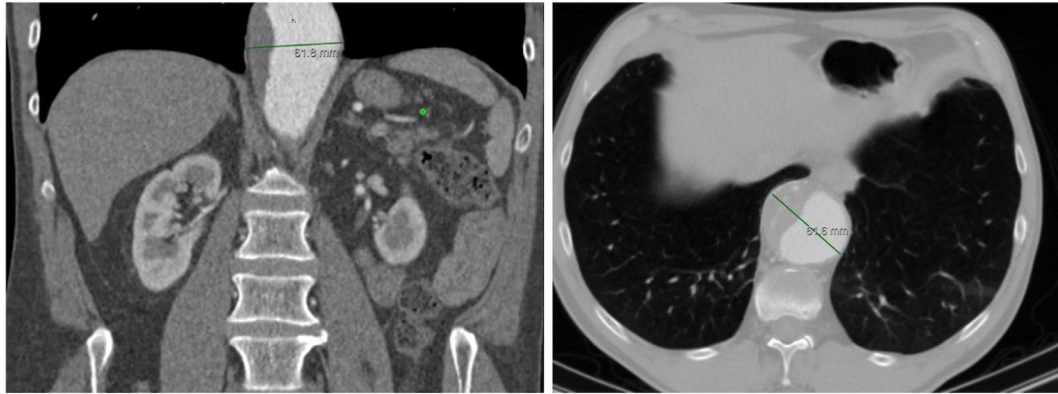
Preoperative computed tomography angiographic images of the patient's thoracoabdominal aortic aneurysm (TAAA).
